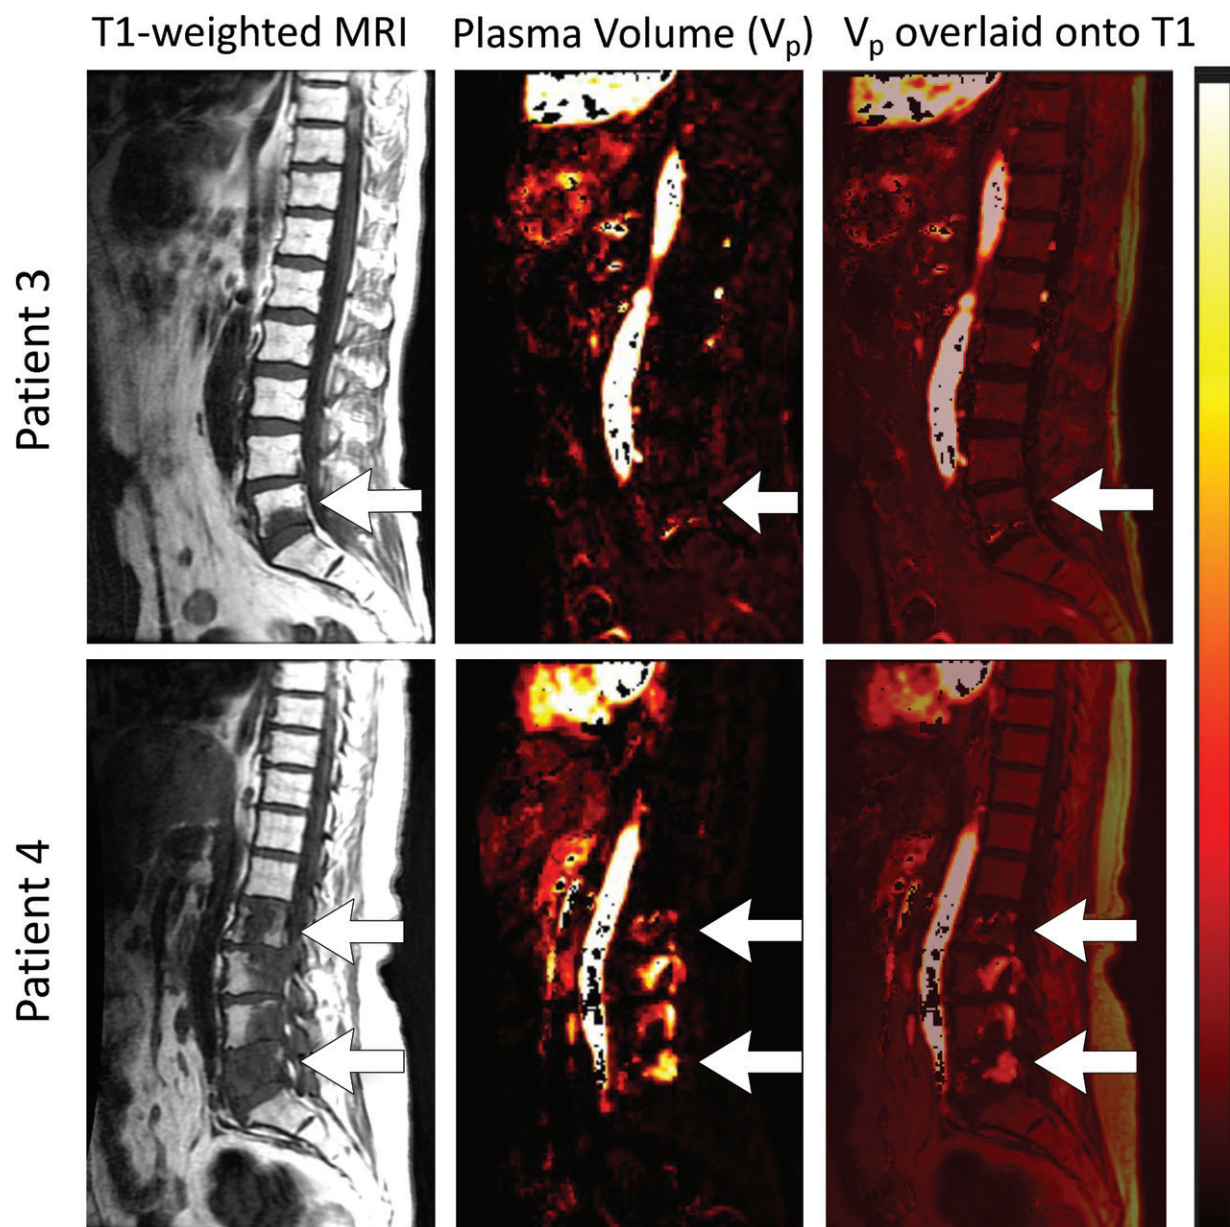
Example of two patients with bladder cancer. In the top row, patient 3 had spinal lesion of bone fragments with marrow fibrosis at L5 (left; arrows). Fractional plasma volume (V_p) maps (middle) and merged T1-weighted MRI and dynamic contrast agent-enhanced perfusion MRI V_p maps (right) of the lesions are shown. In the bottom row, patient 4 had malignant lesions at L2–5 (arrows). The V_p for patient 3 was 1.4, for patient 4 the V_p was 12.2 (L2, L5 averaged).
